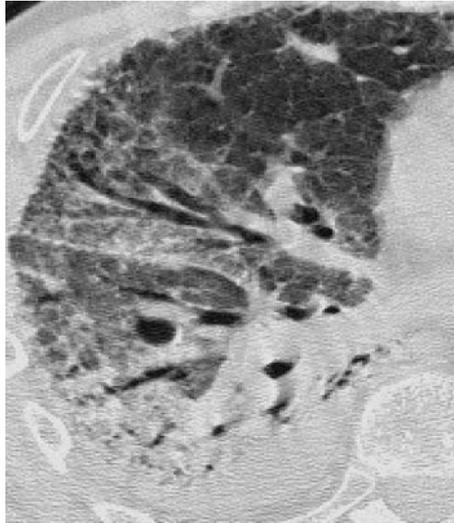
Pneumonia in a patient with a right lung transplant for end-stage emphysema. High-resolution axial CT image, obtained more than 8 weeks after transplantation, shows extensive multifocal ground-glass and airspace opacities within the middle and lower lobes of the right lung. Sputum cultures later revealed the presence of *Candida*.
